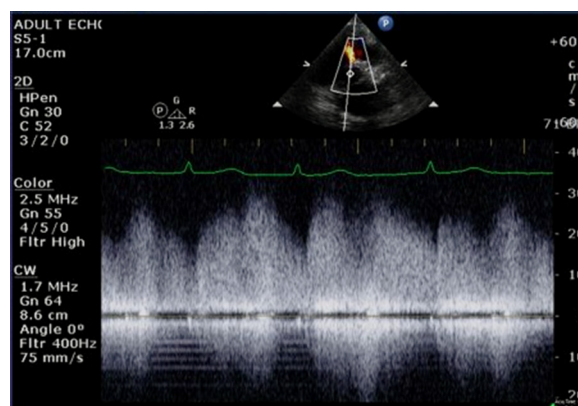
Two-dimensional TTE-guided continuous-wave spectral Doppler display from the parasternal short-axis view demonstrates flow across the shunt that was parallel to the ultrasound beam and ideal for estimation of the maximum velocity. There is continuous flow above the baseline suggestive of flow from the aorta to the RV with a peak velocity measured at 2.9 m/sec.
